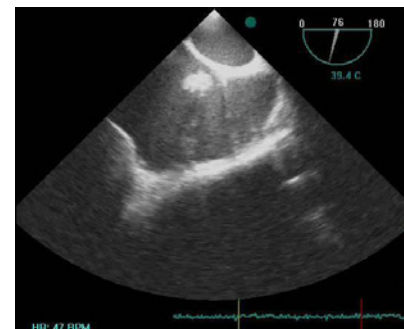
Transesophageal echocardiographic evaluation should be performed in patient with suspected infective endocarditis with revealed no resolution of the mass.
